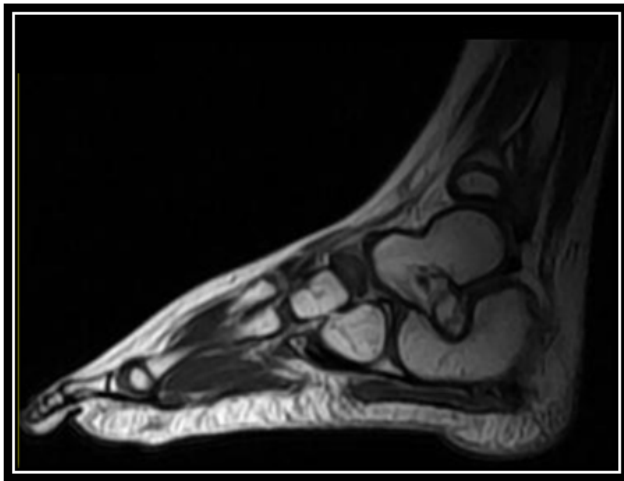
Sagittal view of MRI showing the location of the mass with the cartilaginous cap
